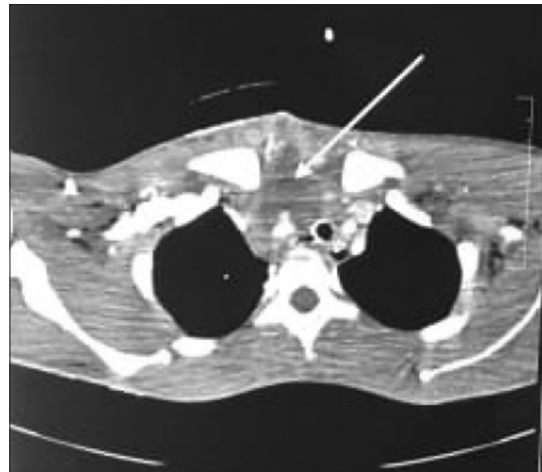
CT angiogram depicting a innominate artery pseudoaneurysm
